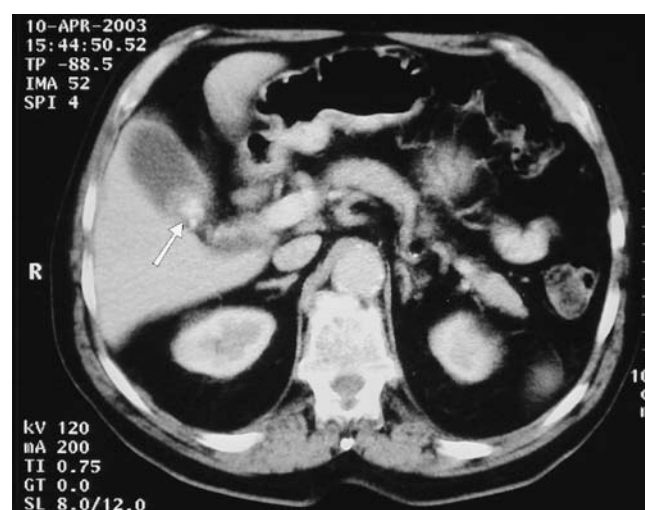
Axial CT-scan at the level of the gallbladder, showing a large calculus within the gallbladder and a further small calculus in adjacent dilated CBD.
